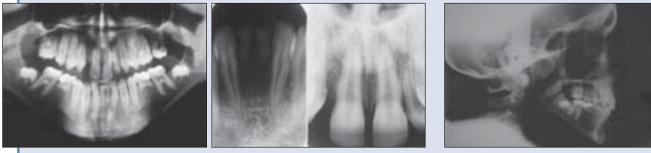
Radiographic views at initial presentation: orthopantomographic view and periapical views of incisor area.
